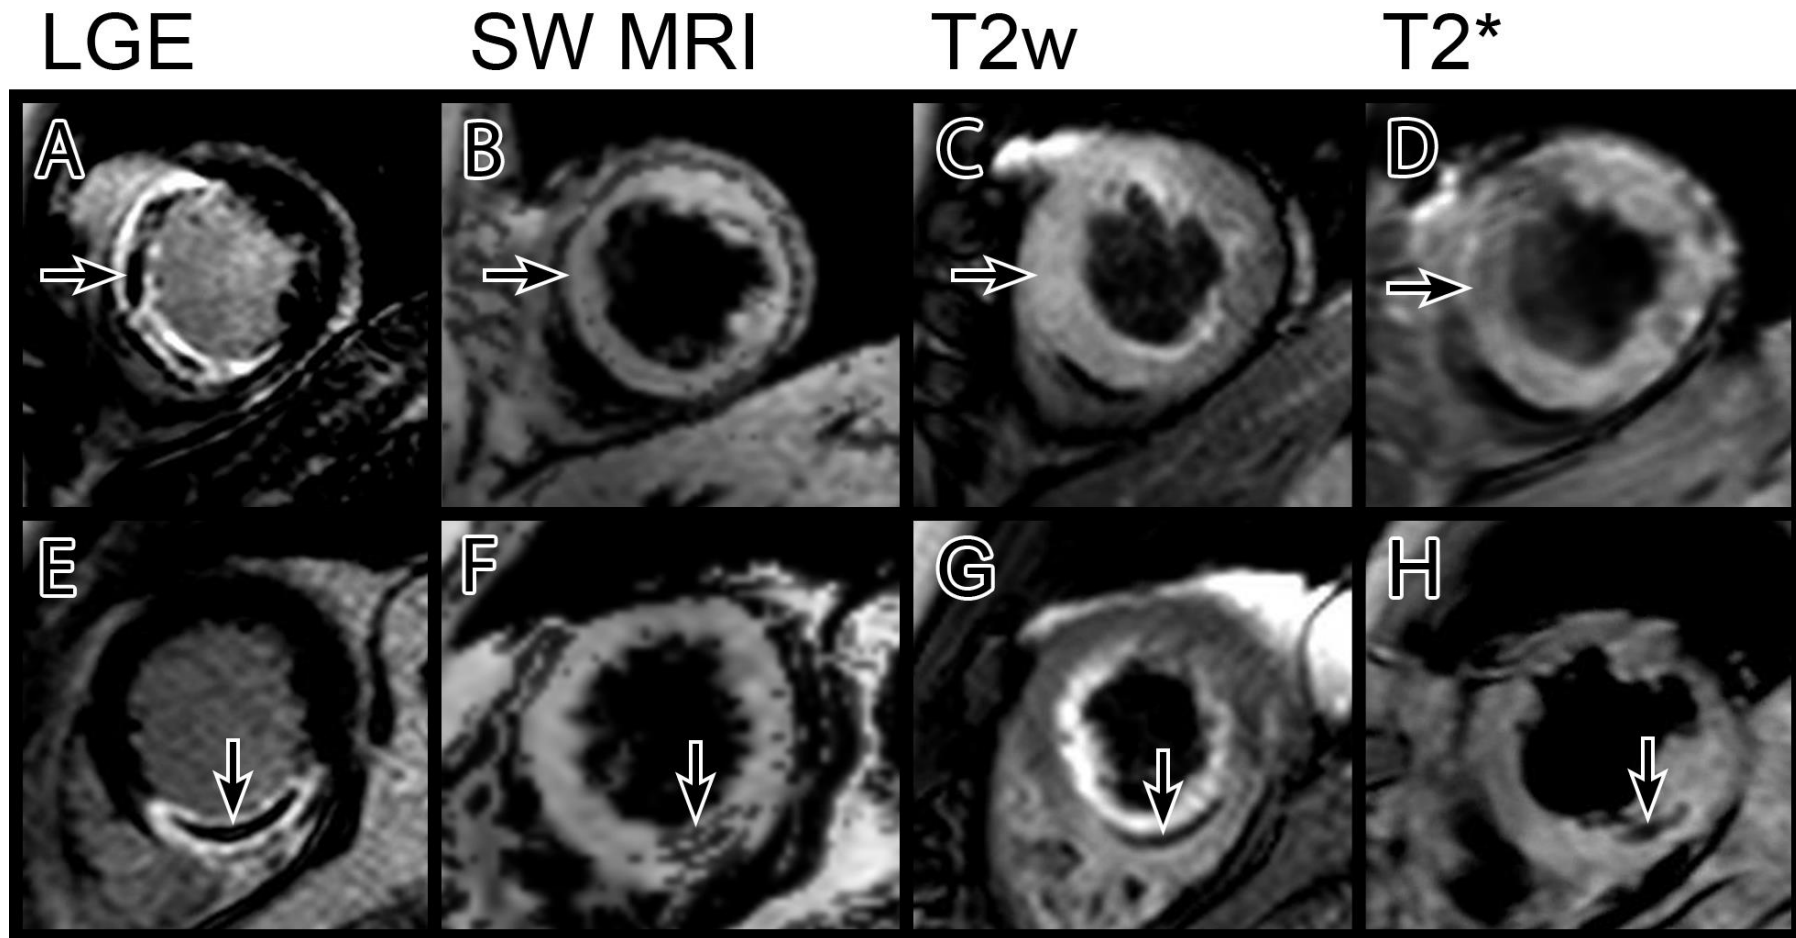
SW MRI imaging comparison with T2w and T2\*. Top row: MO as shown by LGE imaging (A, arrowed) does not correspond to hypointense myocardium indicating absence of IMH on SW MRI (B), T2w (C) and T2\* (D) images. Bottom row: another patient has MO visible on LGE (E, arrowed) corresponding to hypointensity on SW MRI (F, arrowed), T2w (G, arrowed) and T2\* (H, arrowed) images indicating presence of IMH.
